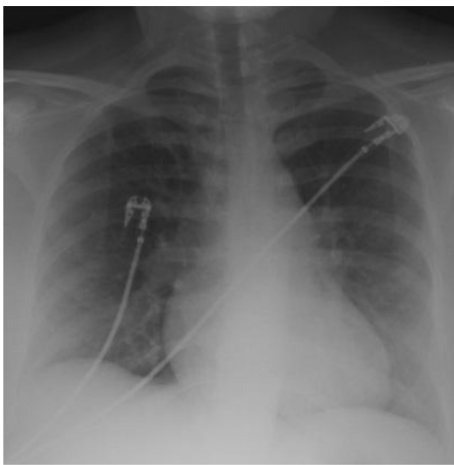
X-ray showing no infiltrate, atelectasis or effusion.
